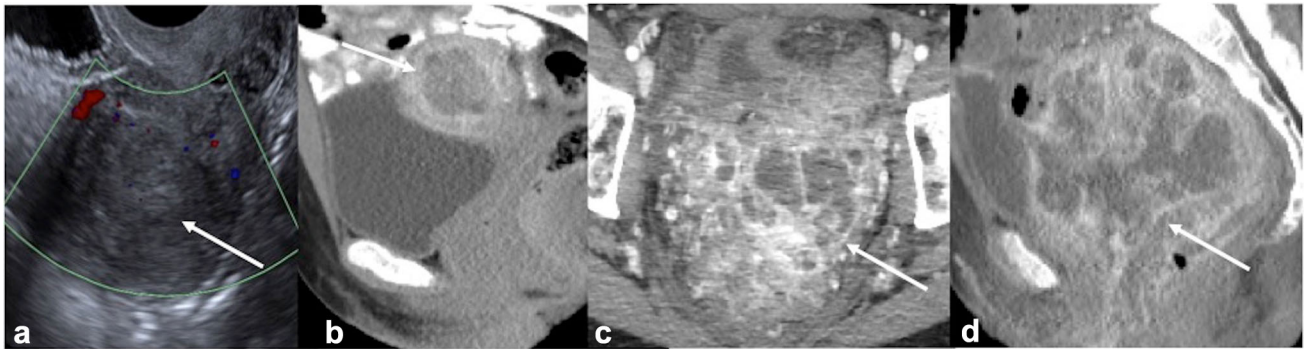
A 62-year-old woman with history of > 5 years of hormone replacement therapy who presented with post-menopausal bleeding. a Transvaginal ultrasound shows large heterogeneous endometrial mass. Endometrial biopsy confirmed high-grade endometrioid adenocarcinoma. b Initial staging CT showed thickened, enhancing endometrium without definite intra-abdominal metastatic disease. Hysterectomy and bilateral salpingo-oophorectomy was performed
